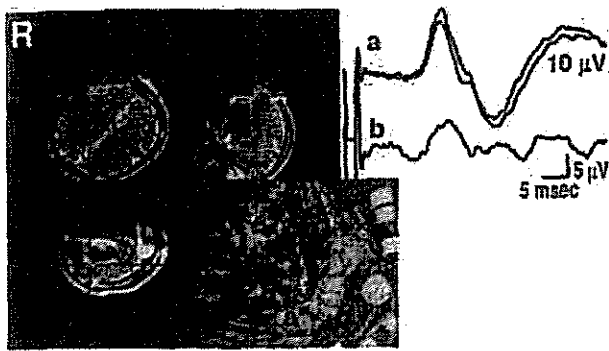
Navigation of three-way bipolar forceps superimposed on intraoperative magnetic resonance images of a patient with right parietal glioma. Somatosensory evoked potential (SEP) traces in a and b correspond to positions a* and b* on the surface image of the brain cortex. Virtual needle on the navigation image shows the location of the bipolar forceps eliciting the SEP in b.
